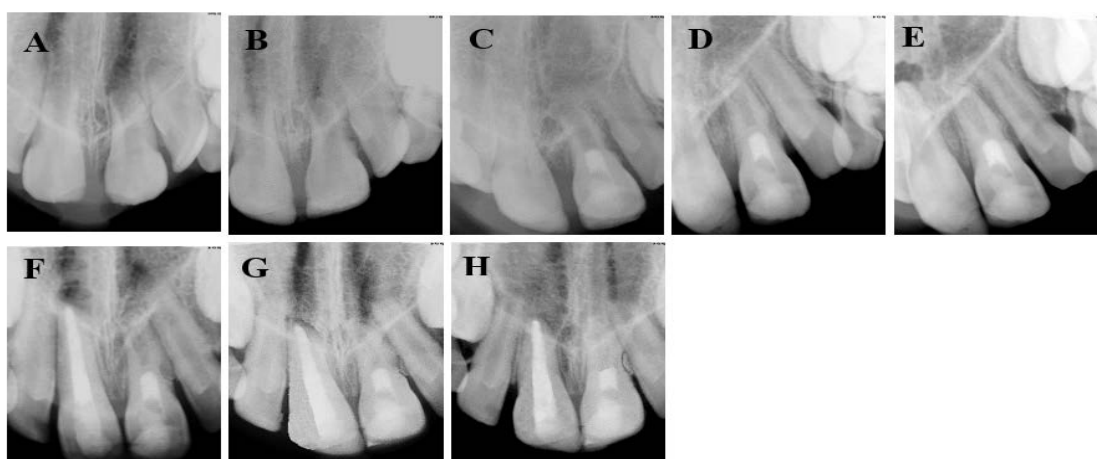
(A) The first-visit radiograph of teeth # 8 and # 9 with uncomplicated crown fractures. (B) Preoperative radiograph of tooth # 9 with external root resorption (C) Postoperative radiograph after VPT of tooth # 9 (D) 3-month post-op follow-up with a dentinal bridge formation at the site of VPT in tooth # 9 (E) 4-month post-op follow-up; in tooth # 9 the inflammatory root resorption was stopped and the lamina dura could be traced around the entire root surface Tooth # 8 had a radiolucent periapical lesion (F) Immediately after obturation of tooth # 8 with MTA plug and thermoplastic gutta percha (G) 6-month post-op follow-up (H) 12-month post-op follow-up; in tooth # 9, a longer and thicker root could be seen and the resorptive lacuna was filled with newly formed bone Re-establishment of a normal periodontal condition could be seen around the whole root surfaces of teeth # 8 and # 9
